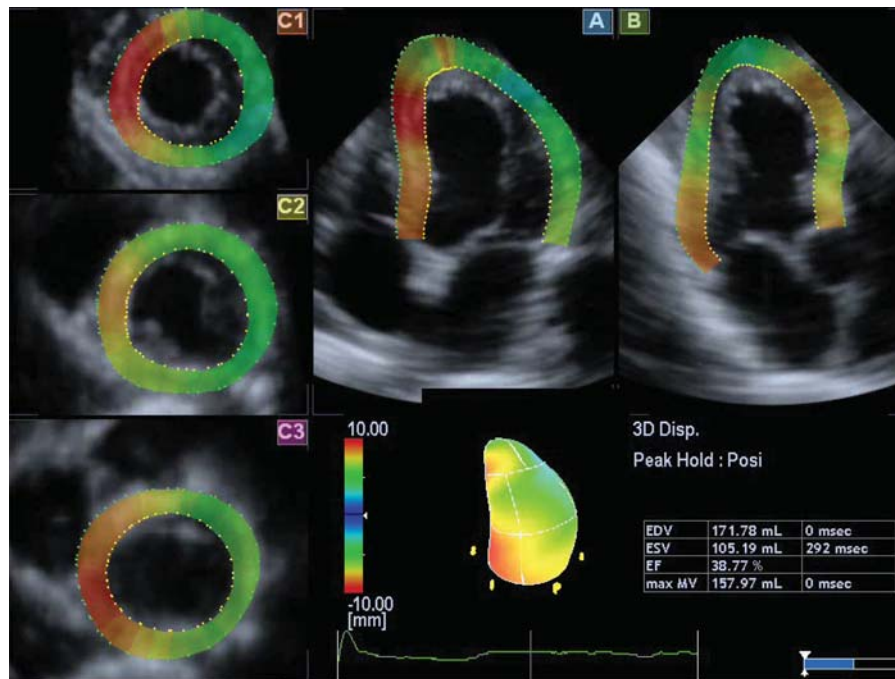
Unlike the images in Figure 10, 3D speckle-tracking echocardiographic slices obtained at end-systole in this patient show reduced 3D displacement in the lateral wall (green hues), consistent with chronic inferolateral myocardial infarction. Reproduced with permission from Nesser et al.²¹
